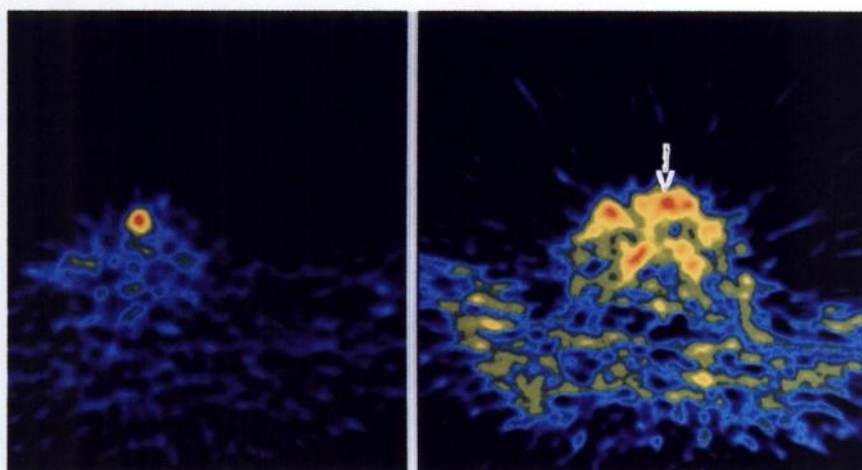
An example of PET images in the fasting state (left) and after glucose loading (right). The laryngeal tumor of Patient 5 (arrow) is clearly visible in the fasting state, but after glucose loading FDG accumulation in the tumor relative to that in the neck muscles is clearly less, making tumor visualization less distinct.
